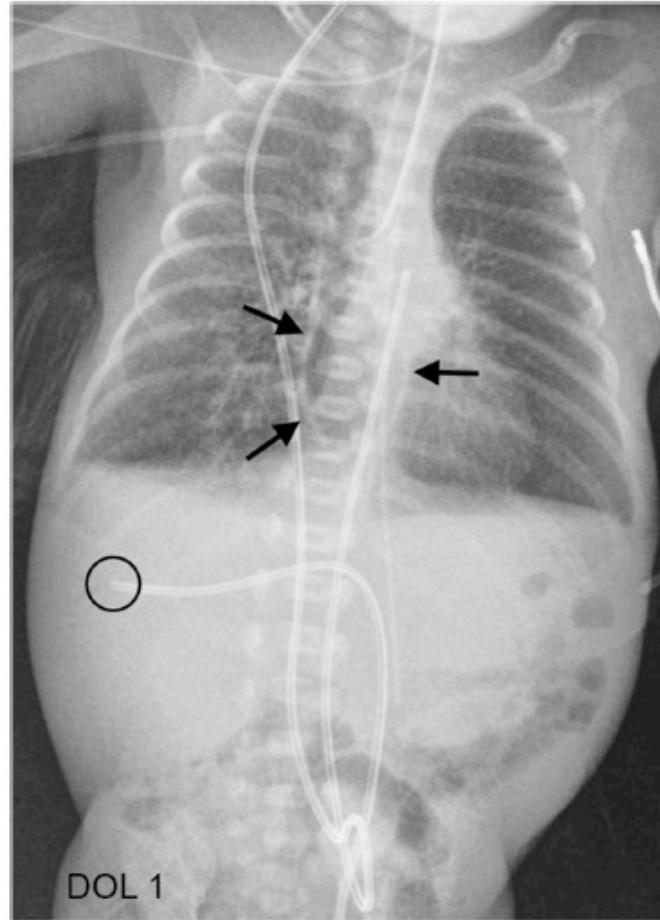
Anteroposterior supine portable chest radiograph immediately after pigtail tube placement from a right posterior paraspinal approach demonstrate the pigtail tube adequately positioned with resolution of retrocardiac pneumomediastinum. There is no pneumothorax. Retained contrast in the colon is from a bedside esophagram performed the day before.
